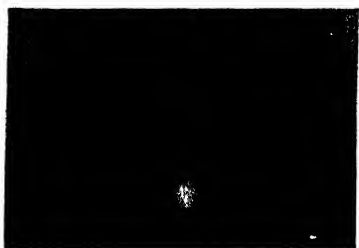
Radiograph showing calculus impacted in the bulbous urethra.
